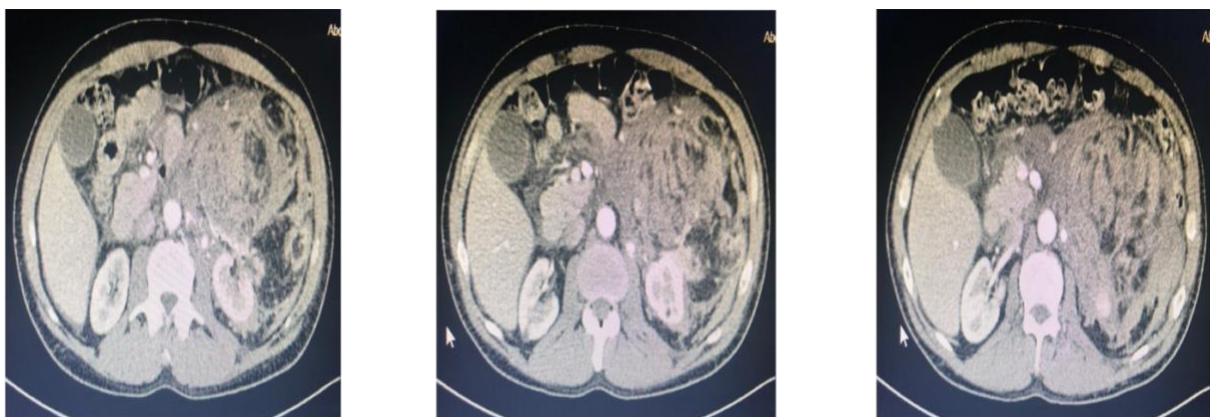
CT scan of the Abdomen and Pelvis with contrast shows left kidney with multiple variable sized heterogenous masses representing multiple renal Angiomyolipoma with adjunct surrounding high density fluid representing contained hematoma.
